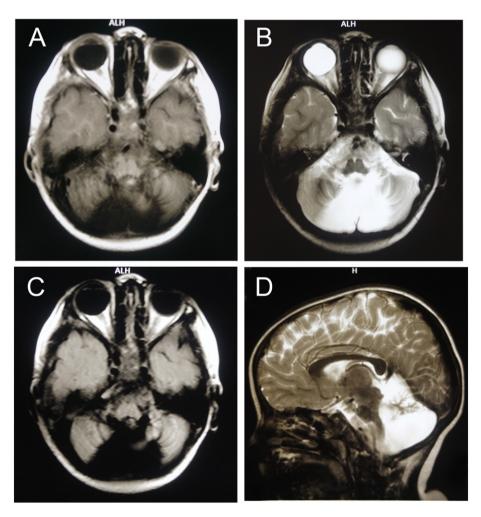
Brain MRI imaging of II-1 Brain MRI features of II-1 demonstrate cerebellar vermis hypoplasia, cerebellar atrophy and fourth ventricle enlargement, the appearance of which is consistent with a Dandy walker variant deformity. A. Axial T1 section; B. Axial T2 section; C. Axial Flair section; D. Sagittal T2 section.
